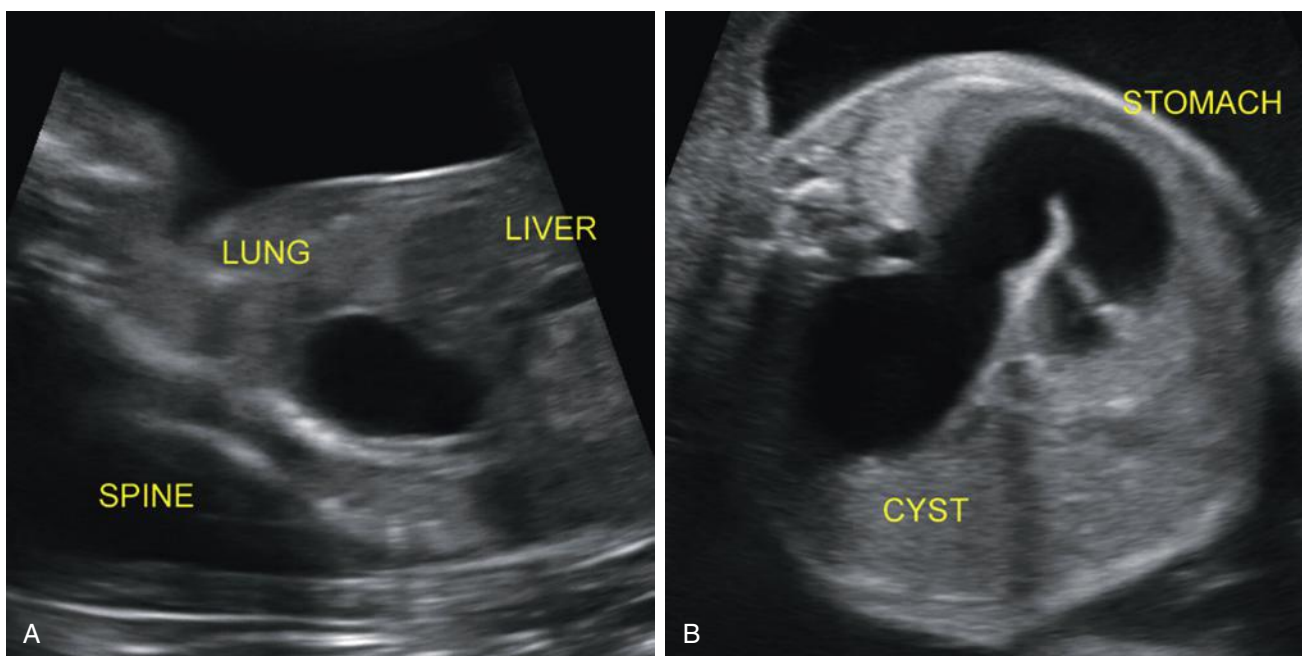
Enteric duplication cyst. A, At 21 weeks, a unilocular anechoic cyst, shown on this parasagittal ultrasound image, extended above and below the level of the diaphragm. B, At 26 weeks, the cyst had enlarged and appeared contiguous with the fluid-filled stomach. The cyst was resected at 3 weeks of age and appeared to originate near the esophageal-gastric junction. Pathologic examination showed it was lined by primitive columnar epithelium with focal areas of gastric epithelium.
